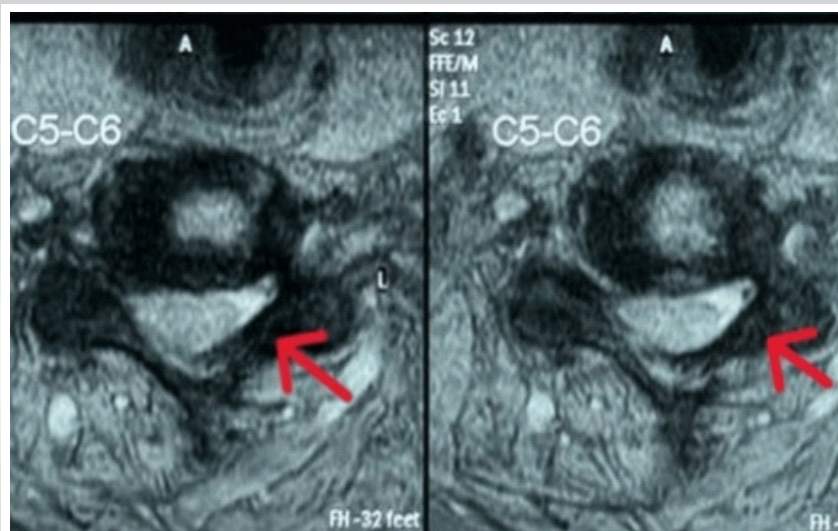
Preoperative axial T2-weighted magnetic resonance image at the C5–C6 level. Axial T2-weighted MRI demonstrating a posterior disc-osteophyte complex causing severe central canal stenosis with marked spinal cord compression and near-complete effacement of the surrounding cerebrospinal fluid (CSF) space (arrows).
